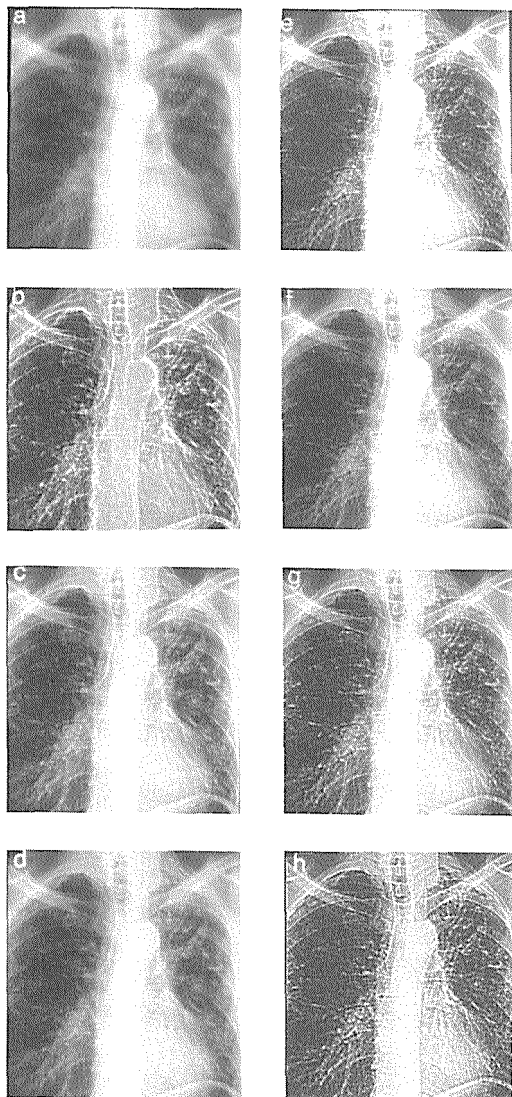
Typical results of the HS algorithm compared to those of others studied. (a) An original chest radiograph of a case of bronchiectasis. Result after processing with histogram shifting of (b) $f = 0.9$, HS 0.9. (c) $f = 0.7$, HS 0.7, and (d) $f = 0.5$, HS 0.5. Result after processing with (e) linear high pass filter, HP2; (f) unsharp masking, UM 0.6; (g) homomorphic; HM2; and (h) statistical differencing, SD 0.1.
